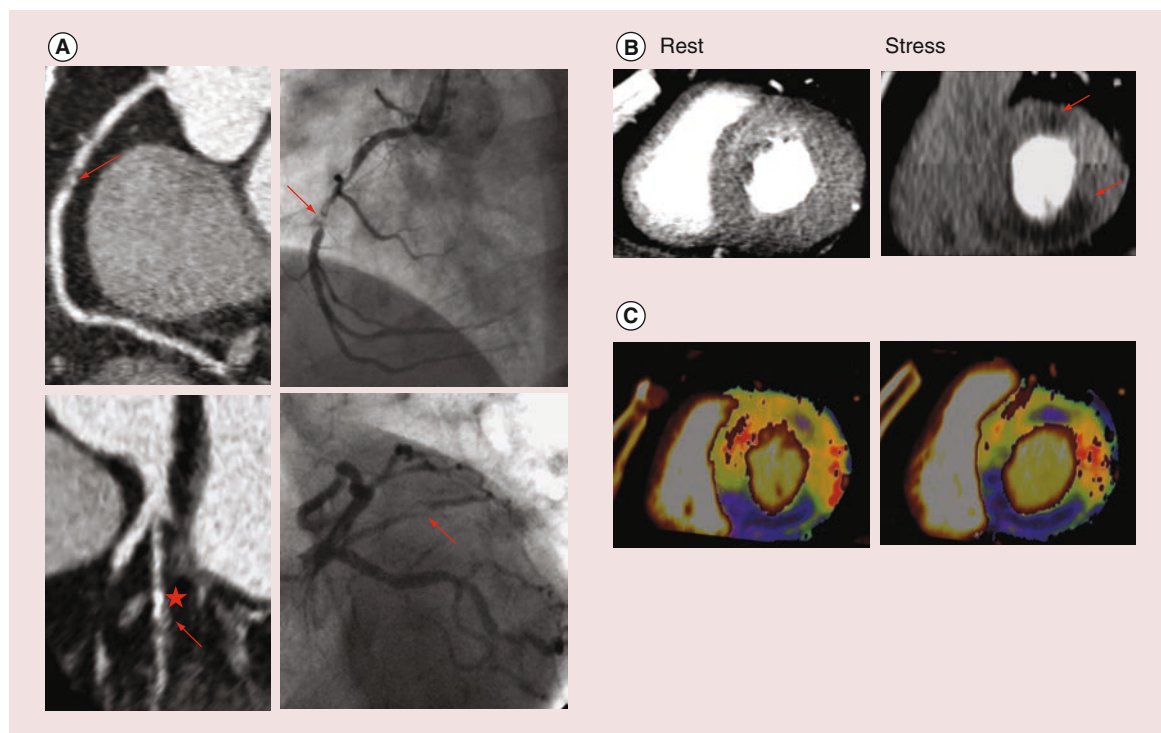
Example of comprehensive assessment of anatomic stenosis and hemodynamic significance using dynamic computed tomography-myocardial perfusion imaging. (A) Reconstructed cCTA images and invasive coronary angiography showing stenotic lesions (red arrows) of RCA and RI. Note that the presence of heavy calcification (red asterisk) hampers accurate measures of stenosis severity in the RI lesion, whereas cCTA clearly visualize the near total occlusion of mid RCA. (B) Rest and stress CT-MPI depicting reversible myocardial perfusion defects in territories of RCA and RI (red arrows). Perfusion defects are presented in RI territory as well as RCA territory, suggesting both stenoses are flow-limiting. Note that a prominent misregistration artifact on the stress image. This artifact can be developed by the integration of images in different cardiac phases, if two image acquisitions are required to perform dynamic CT-MPI. Thus, the misregistration artifact is not found on static CT-MPI images, and it can also be avoided with a dynamic scanner capable of covering the entire heart by a single image acquisition. (C) Quantitative color map representing the distribution of myocardial blood flow. Blue color of RCA and RI territories indicates the reduction of myocardial blood flow in these coronary territories. cCTA: Coronary CT angiography; CT: Computed tomography; CT-MPI: Computed tomography-myocardial perfusion imaging; RCA: Right coronary artery; RI: Ramus intermedius. Images were provided by Dong Hyun Yang from Asan Medical Center, South Korea.
